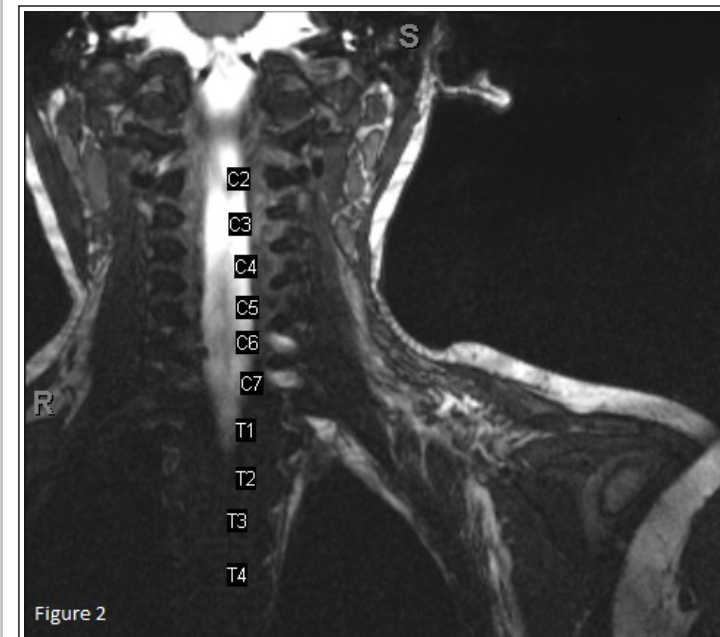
Left MRI Brachial Plexus Ultrafast Spin Echo Sequence demonstrates proximal nerve root
